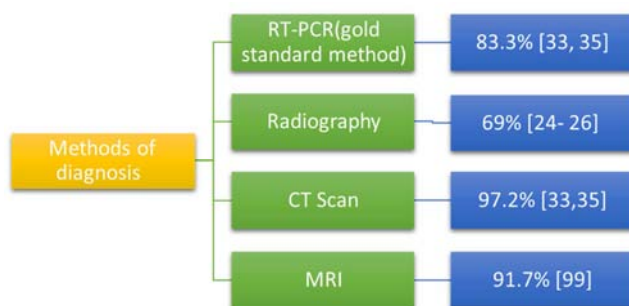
Sensitivity percentage of Coronavirus diagnostic methods. As it shows in the above, the sensitivity of Radiography images is lower than the RT-PCR test.
